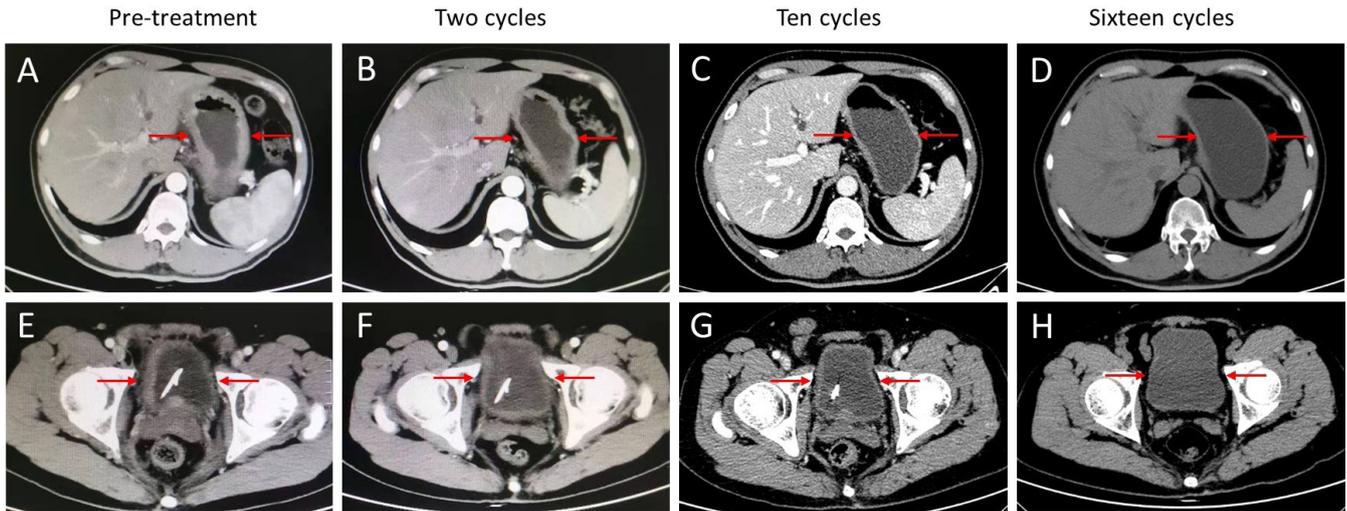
CT findings of patient 6 before and after treatment of combination regimens. Aberrant thickened stomach wall marked by red arrow (A) and bladder wall marked by red arrow (E) could be observed. After combination treatment, the thickened stomach wall (B-D) and bladder wall (F-H) gradually became thinner. CT, computed tomography.
